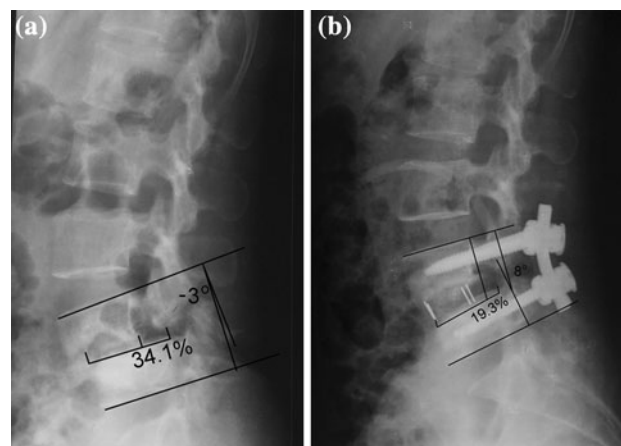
A 53-year-old woman with grade II isthmic spondylolisthesis was surgically treated with PLIF in situ. Preoperative lateral X-ray showed that slippage was 34.1 % and focal lordosis was -3.0° (a). Postoperative X-ray showed that disk space distracted with olisthesis partially reduced to 19.3 % and focal lordosis increased to 8° (b)
